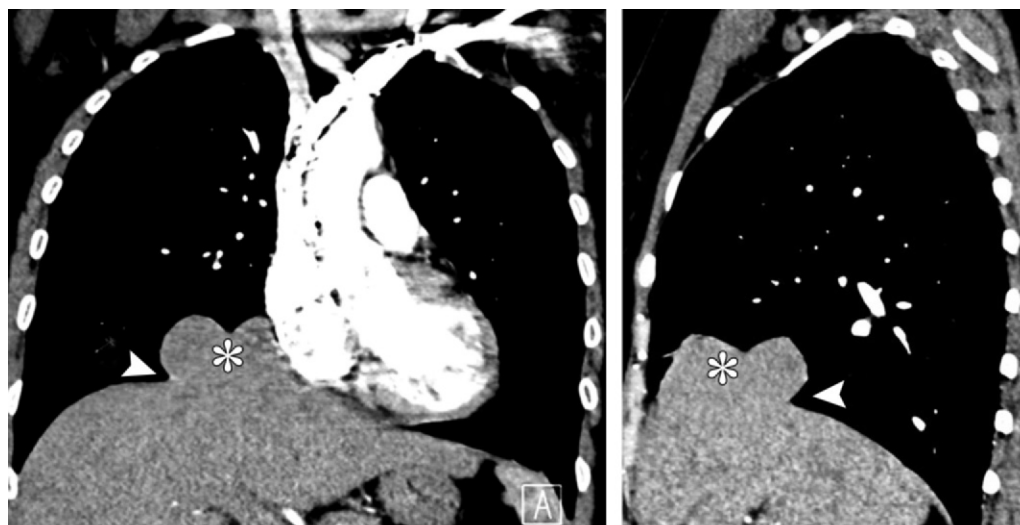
Right-sided BDR discovered incidentally in a 43-year-old woman 10 years after severe thoracoabdominal trauma due to a motor vehicle accident. Coronal (a) and sagittal (b) contrast-enhanced reformatted CT images show herniation of part of the liver dome (*) into the thorax through a small anterior defect, which is evident from the focal constriction of herniated liver (collar sign) (arrowhead). A posttraumatic pseudoaneurysm with a diameter of 35 mm also was seen at the level of the aortic isthmus (not shown).
